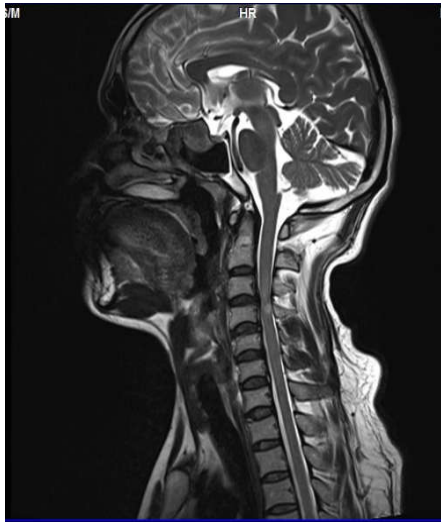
CT scan of the patient with compression at C3-4 level
